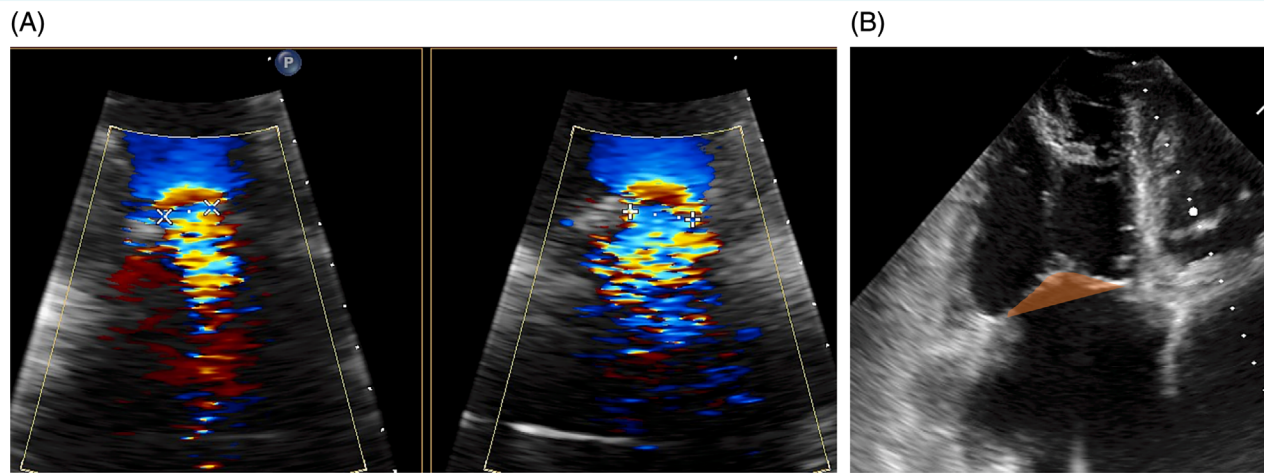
Example of a patient with high probability of residual tricuspid regurgitation $\geq 3+$ after tricuspid transcatheter edge-to-edge repair. Tricuspid regurgitation vena contracta and tricuspid valve tenting area were measured in a right ventricular focused apical four-chamber view. (A) Measurement of biplane vena contracta, and (B) measurement of tricuspid valve tenting area.
